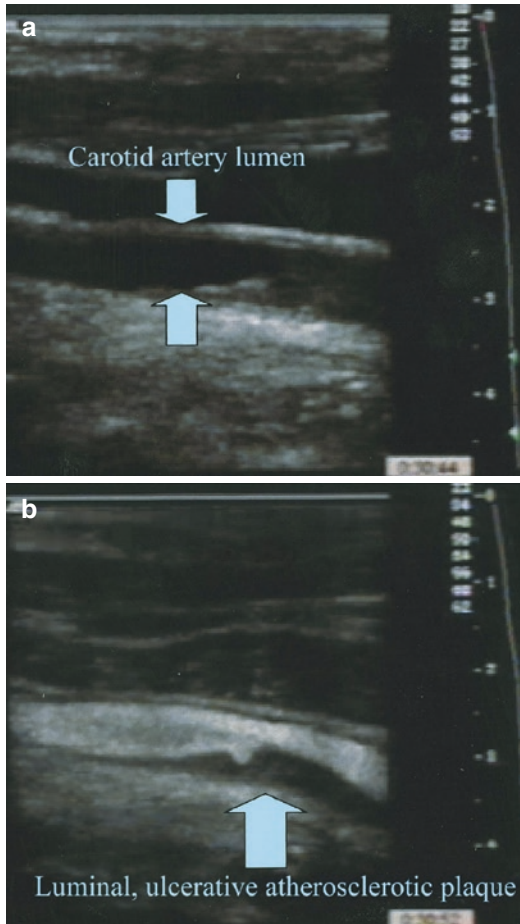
B-mode ultrasound showing the lumen of the carotid artery without contrast (a) and with ultrasound contrast (b). The lumen appears as an echo-dense (white) structure along with ulcerative plaque. Feinstein [67]
